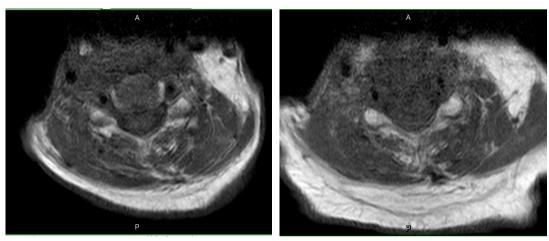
Coronal view of Cervical MRI C6, C7
